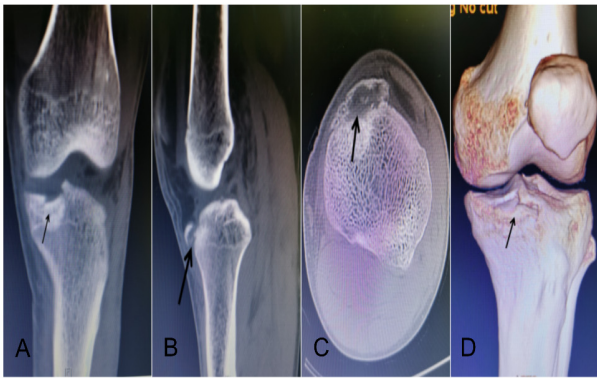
A, Front view of the initial injury: the left tibial plateau fractures and collapses. B, The initial injury side view shows a fracture of the left tibial plateau with displacement and a small fracture. C, CT of the initial injury showing a fracture of the anteromedial edge of the left tibial plateau with displacement. D, The three-dimensional reconstruction of the initial injury showing a fracture of the anteromedial edge of the left tibial plateau with displacement. "→" indicating damage location.
